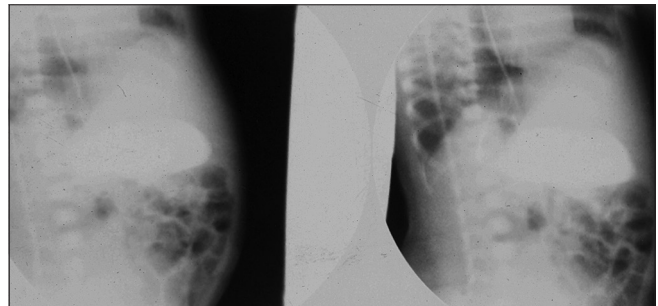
Neonatal abdominal radiograph with oral contrast: The radiograph of the abdomen with oral contrast showed no definite mass lesion
